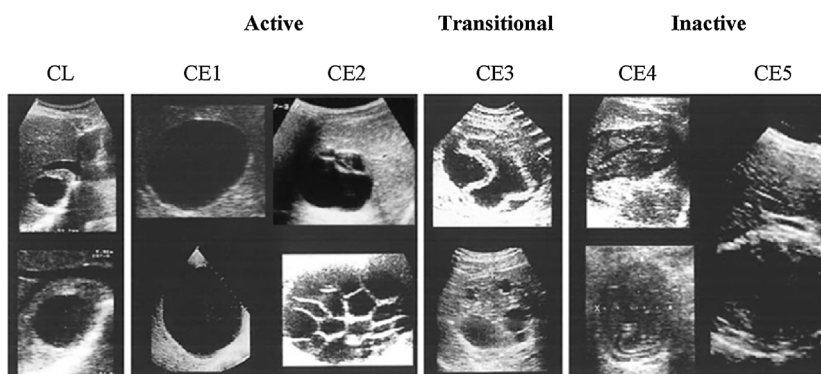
WHO-IWGE ultrasound classification of cystic echinococcosis (WHO-IWGE, 2003, 2017; Brunetti et al., 2010) (adapted).
